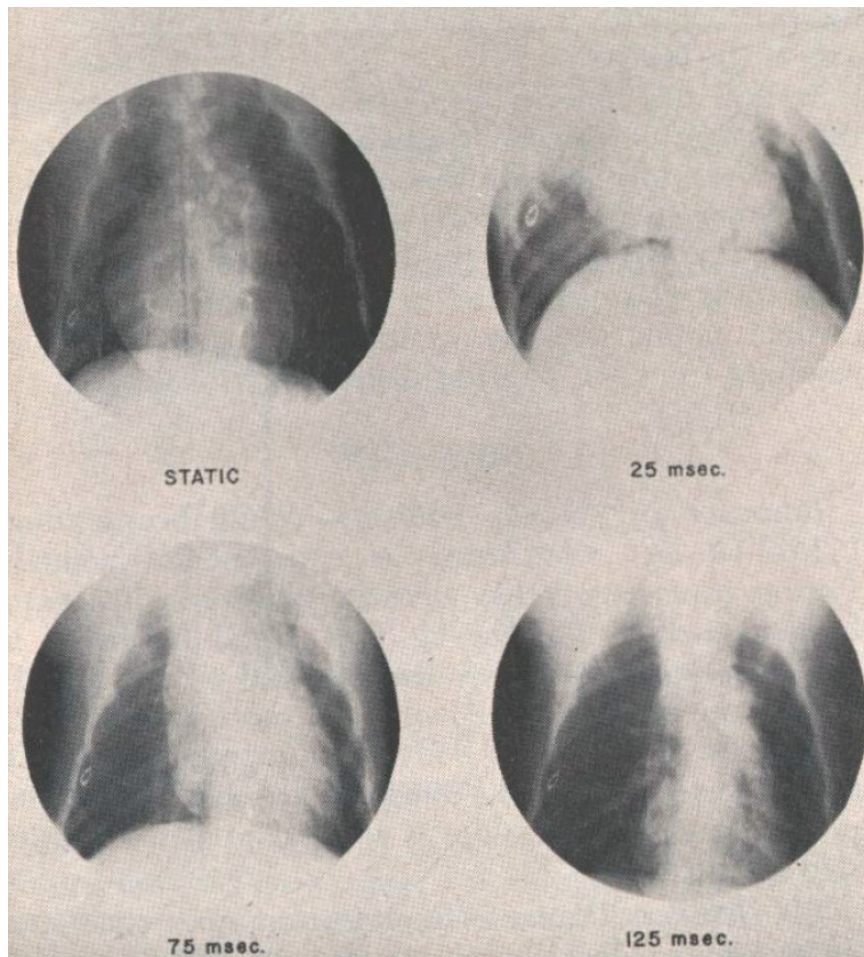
Thoracic radiographs showing relative motion of the heart and diaphragm during G_z acceleration. From Hanson (1967).
